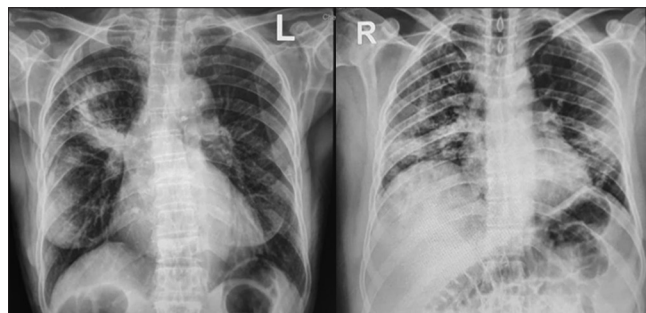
Chest X-Ray imaging from Patient 1 (Left) and Patient four (Right)
